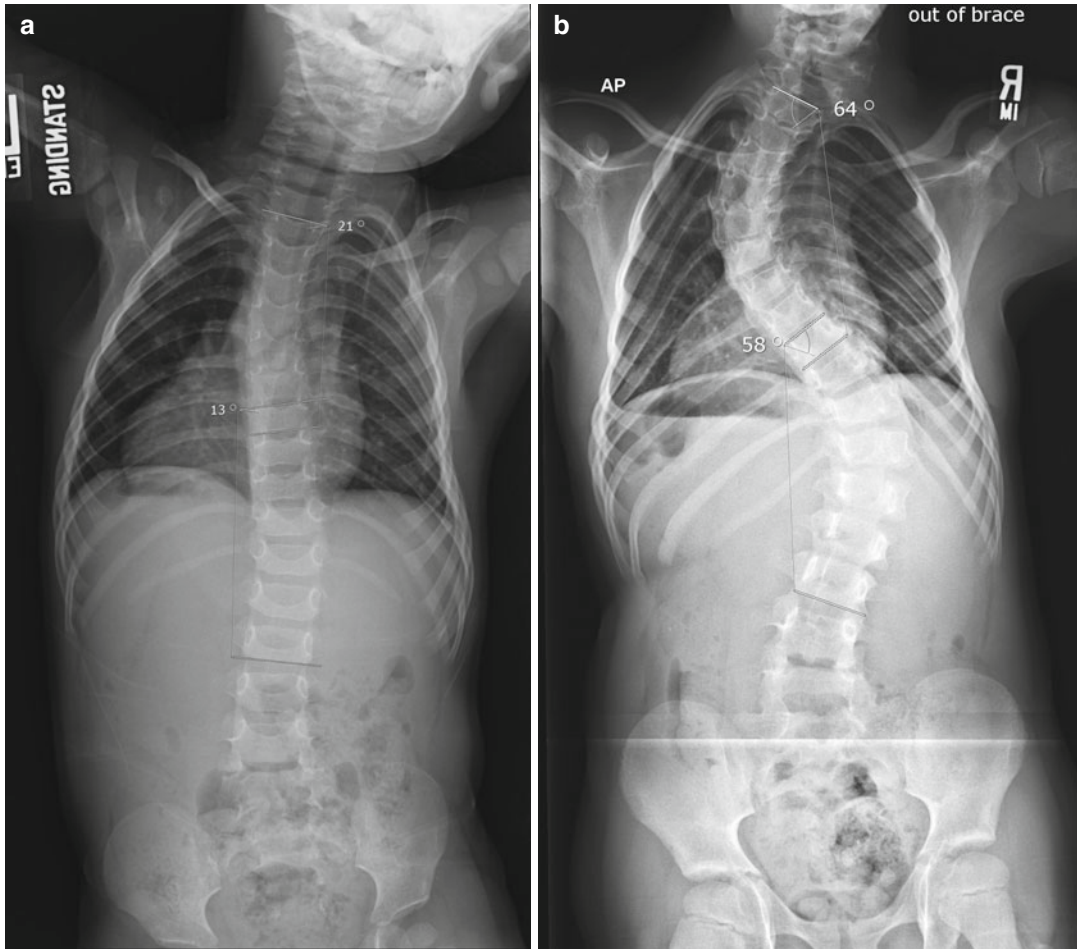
(a) A 20-month-old male with syndromic, hypotonic scoliosis. First standing radiograph. Rib morphology is unremarkable. (b) Age 7, spine deformity has
